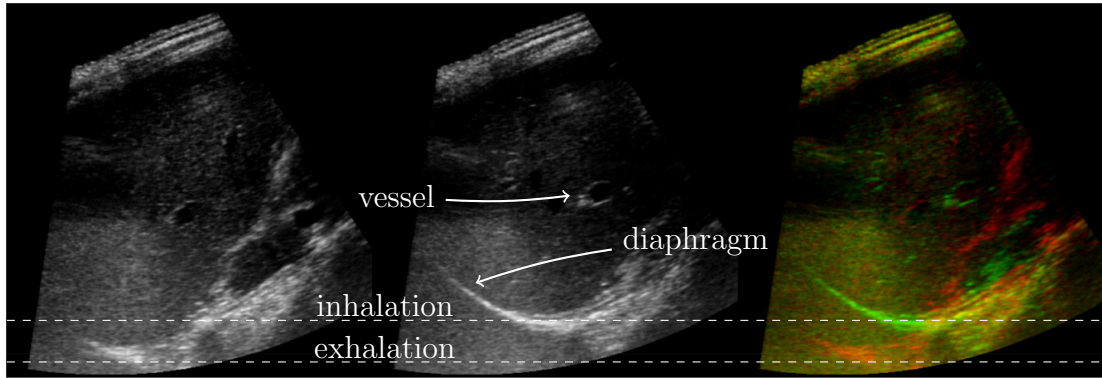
Ultrasound as a modality for image-guided therapy. The above images depict a liver at exhalation (left) and at inhalation (middle). The diaphragm is clearly visible in both images and is therefore suitable for tracking the respiratory state. Additionally, several liver vessels are visible and can be used for tracking as well. The right image shows an overlay of both images.
